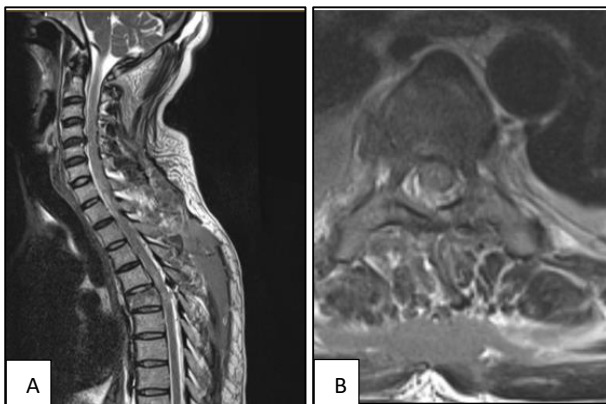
(A-B): Preoperative T2 weighted section of the MRI showing flexion distraction injury at the T5 level. Sagittal section and axial section showing the involvement of all three columns of the spinal cord.
